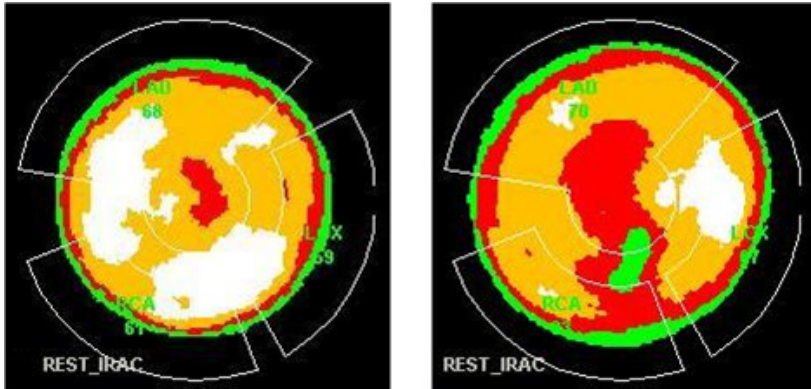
Bull's-eye displays of myocardial SPECT perfusion studies. Normal perfusion (left) and hypo-perfusion of inferior wall (right). The colours indicate the degree of perfusion, with white — normal, orange — acceptable, red — hypo-perfused, and green — no perfusion. Also indicated are the perfusion areas for the main coronary vessels LAD, LCX and RCA. (Courtesy of B. König, Hanuschkrankenhaus, Vienna.)
